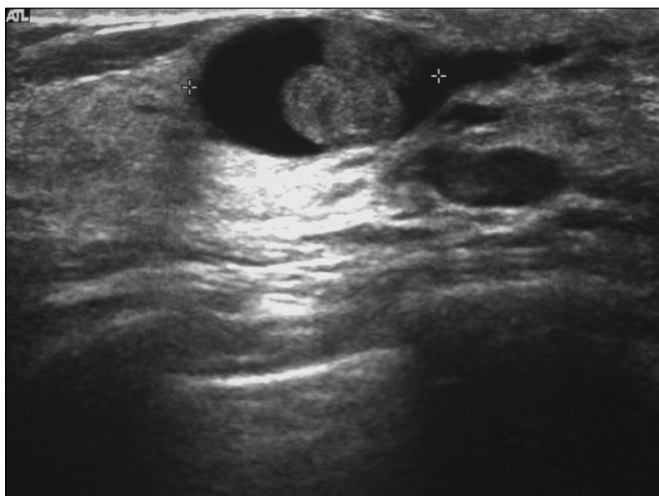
Intraductal papillomata; ultrasound image of two small papillomata within a distended duct close to the nipple; patient presented with discharge.
